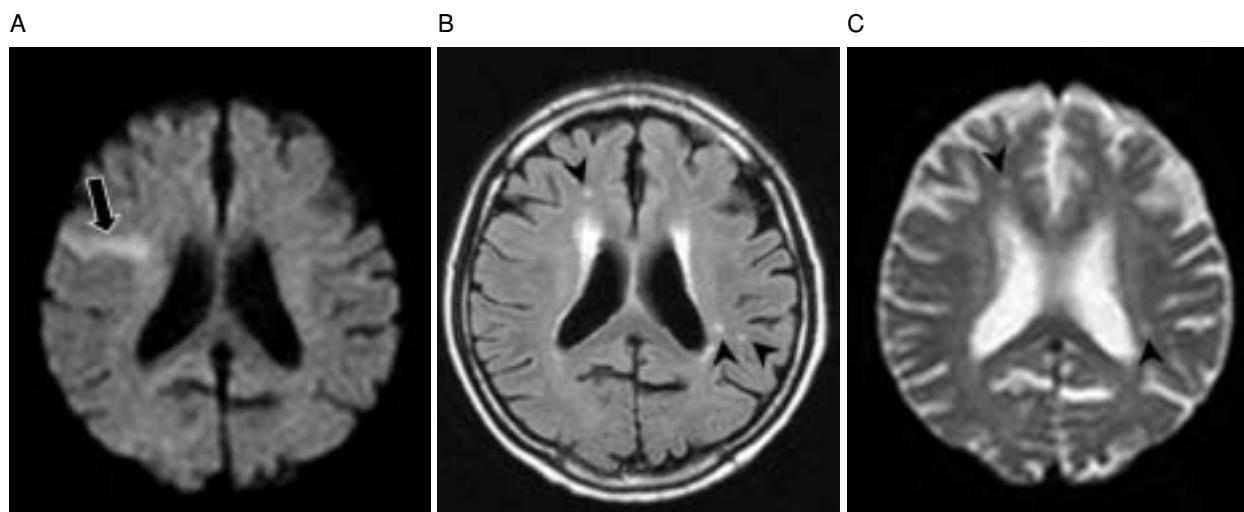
Magnetic resonance images on hospital day 8
